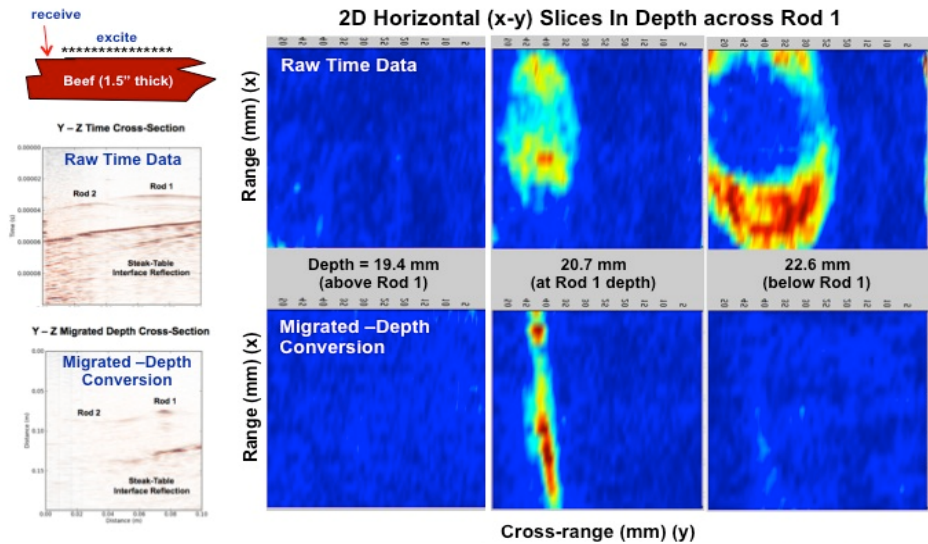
2D Sonogram and 3D Depth Migrated Images of embedded rods in steak sample. Migration algorithm reduces time distortion and image spreading due to diffraction scattering.
